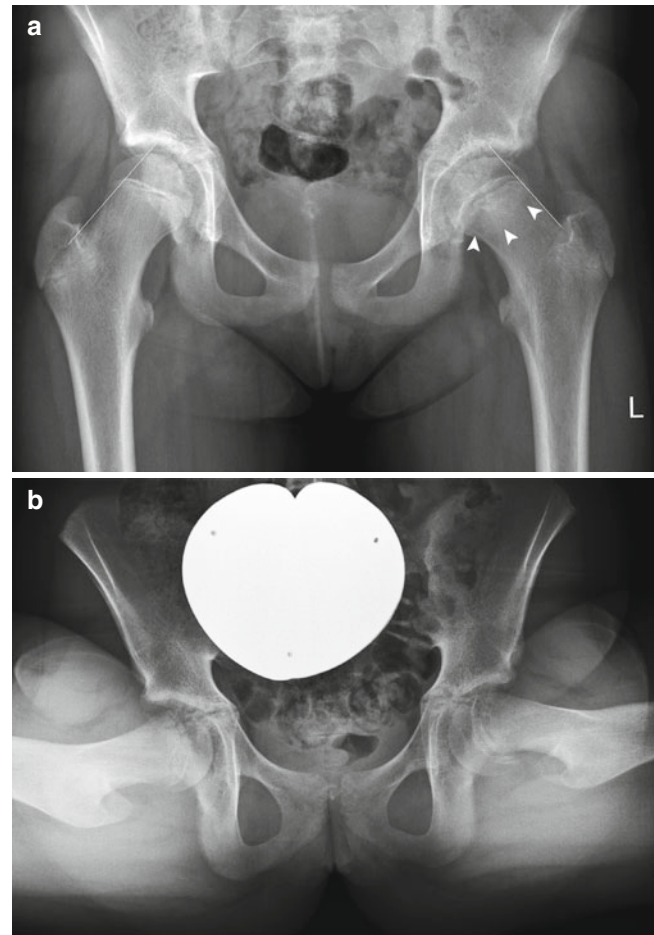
(a) AP pelvis radiograph of a mild slip. The physis is widened and more of the femoral head is medial to Klein’s line when compared to the contralateral side. Steel’s sign, increased metaphyseal density (arrow heads) is also visible. (b) The slip is clearly visible on the frog lateral radiograph
